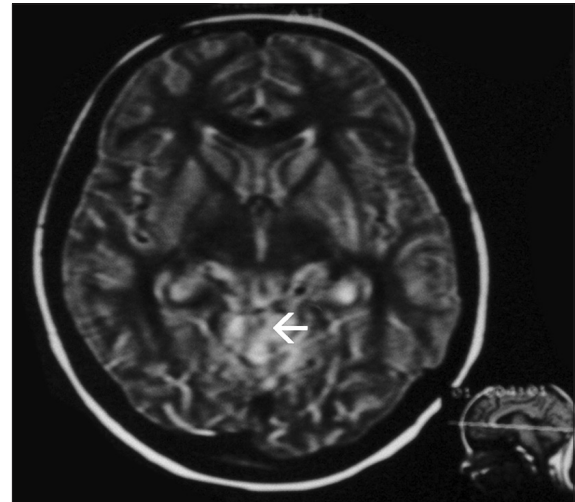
MRI Brain T1 Flair sequence showing altered signal intensity (arrow) in cisterns around the brainstem
